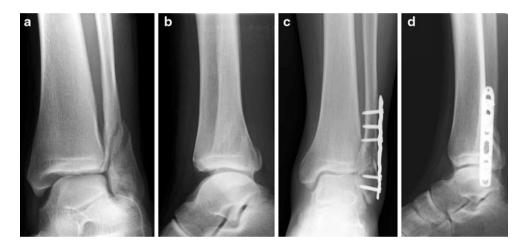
M.M., male, aged 73, case 13 Tables 2, 3 and 4: a, b preoperative X-ray; c, d follow-up 8 months later
